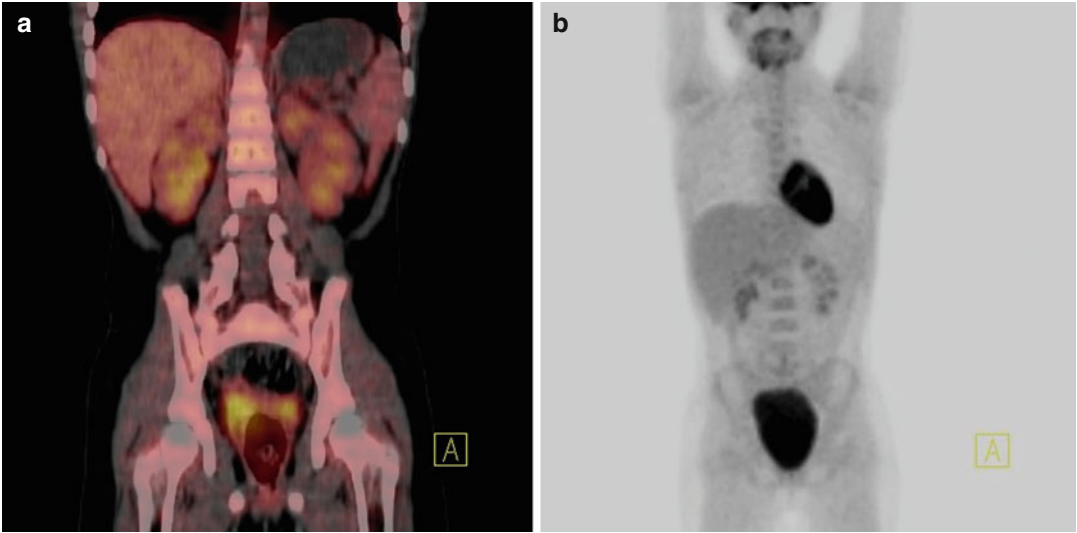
PET/CT images (a, b) at the end of treatment show complete remission of the disease
